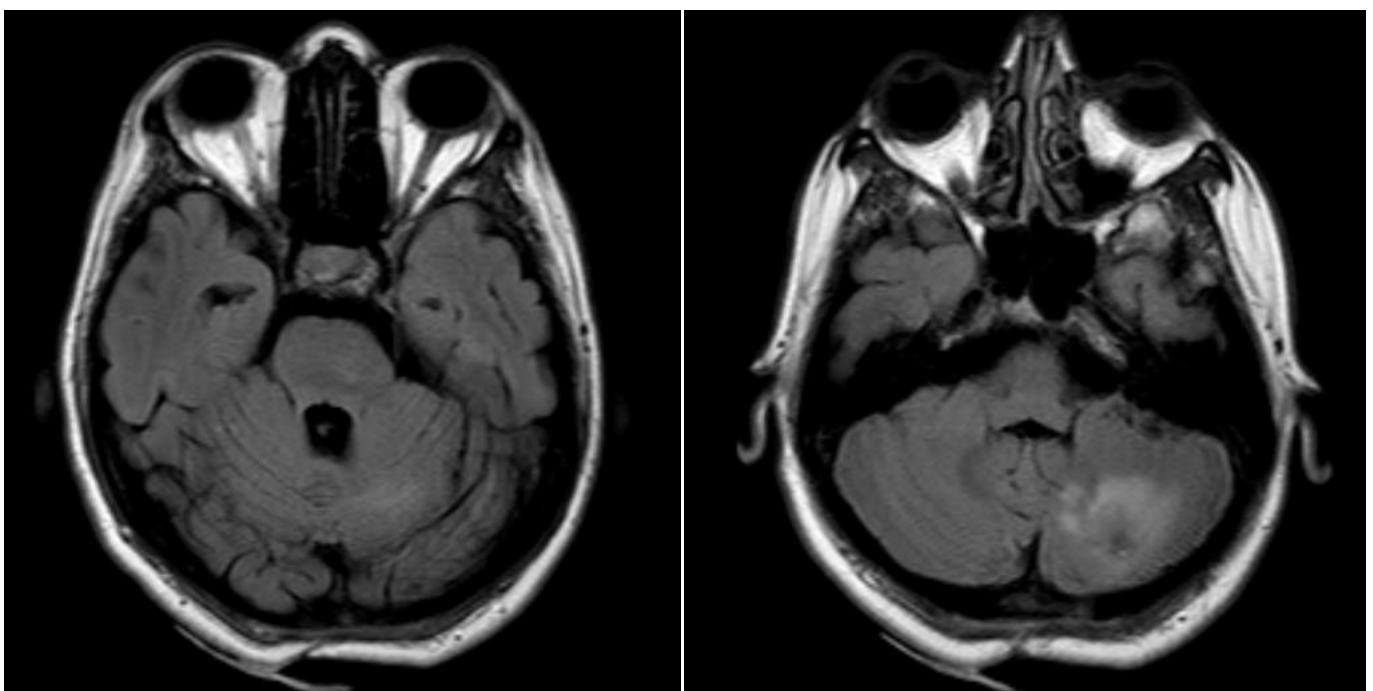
Postoperative cerebellar image. In contrast-enhanced cranial MR images, cerebellar abscess was regressed
